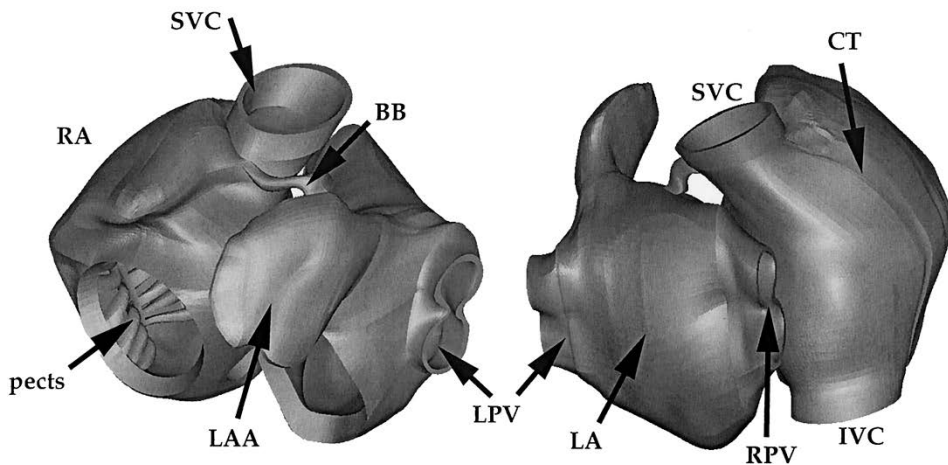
Anterior (*left*) and posterior (*right*) views of a CAD model corresponding to the first 3D cardiac computational model of human atria. RA: right atrium. LA: left atrium. pects: pectinate muscles. SVC: superior vena cava. IVC: inferior vena cava. LPV: left pulmonary vein. RPV: right pulmonary vein. BB: Bachmann's bundle. CT: crista terminalis. Reproduced from (Harrild and Henriquez, 2000)
